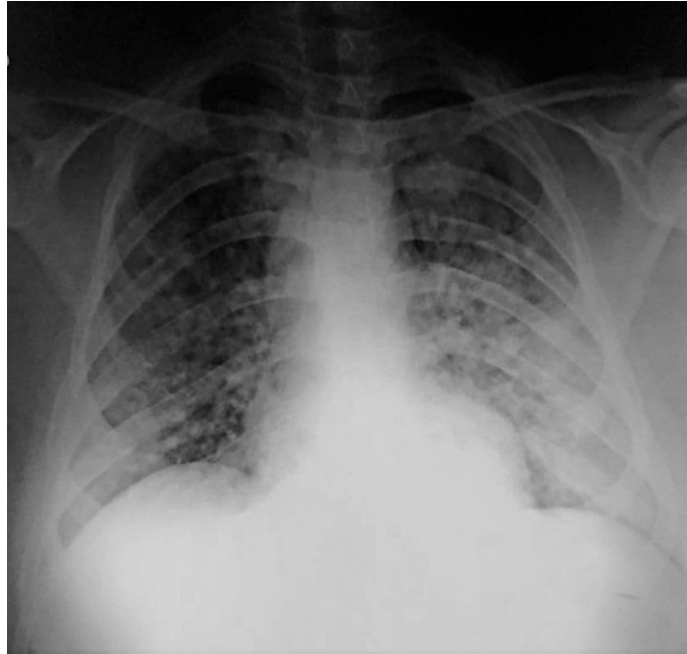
X-Ray chest PA view showing haziness in B/L mid and lower zones
